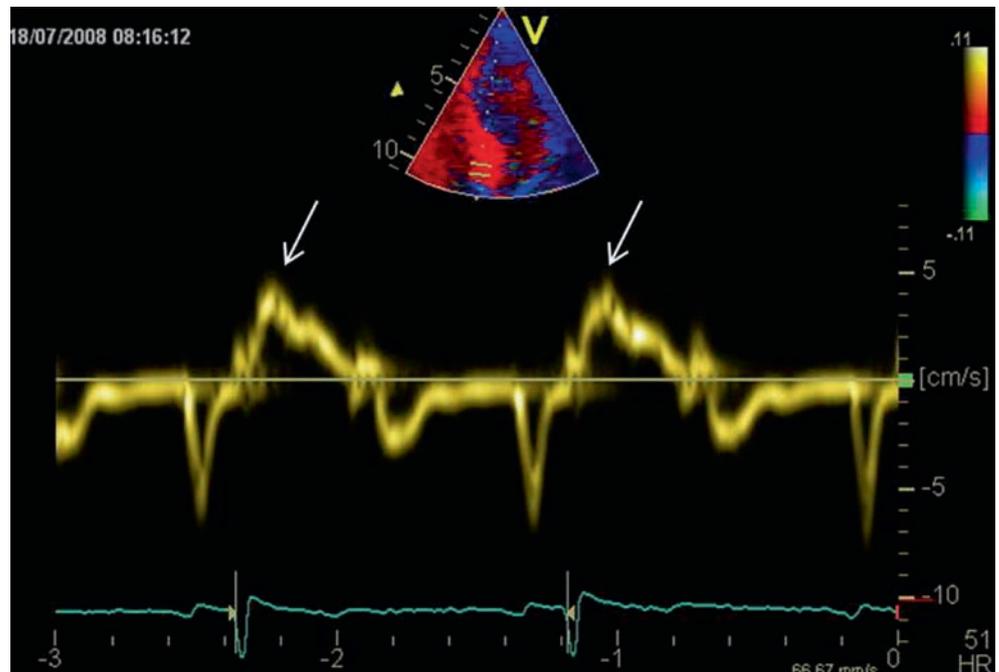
Recording of pulsed tissue Doppler from septal mitral annulus in a patient with severe aortic stenosis. S wave velocity is significantly reduced signifying an impaired longitudinal function, despite a preserved global left ventricular ejection fraction
